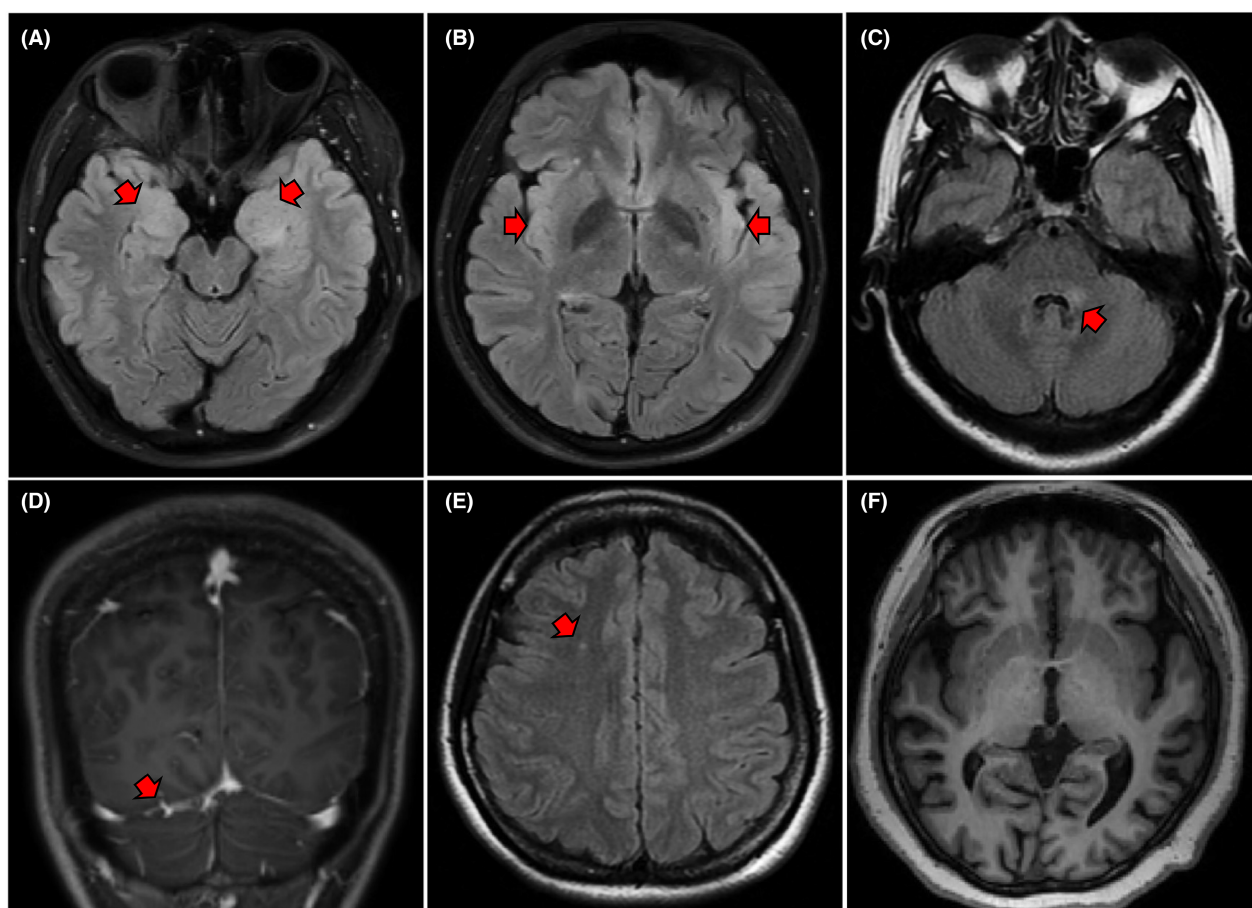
Neuroimaging features of routine MRI studies in anti-mGluR5 encephalitis. (A) T2/FLAIR hyperintensities in the bilateral medial temporal lobes including both amygdala and hippocampus. (B) T2/FLAIR hyperintensities in bilateral insular lobes. (C:) T2/FLAIR hyperintensity in left brachium pontis. (D) Mild enhancement in the right tentorium cerebelli. (E) Small punctuate white matter T2/FLAIR hyperintensity in the right frontal lobe in a 30-year-old patient. (F) Global atrophy in T1 sequence in a 46-year-old patient.
